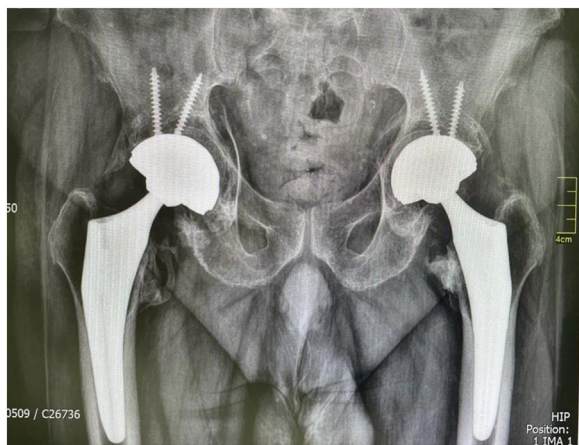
Six-month follow-up pelvis anteroposterior radiograph.
